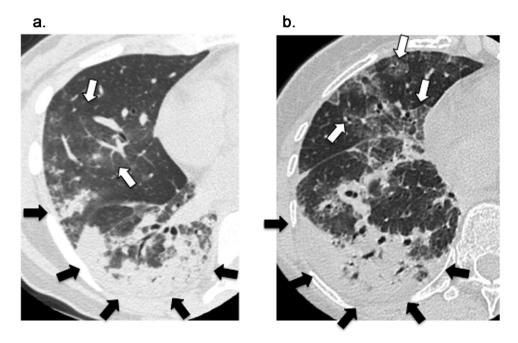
Airspace consolidation. (a) Thin-section CT scan of the right lung in a 43-year-old woman with ARS-ILD (EJ) shows areas of airspace consolidation in peripheral and peribronchovascular regions (black arrows). Areas with ground-glass attenuation are seen around those of airspace consolidation (white arrows). (b) Thin-section CT scan of the right lung in a 66-year-old man with ARS-ILD (Jo-1) presents areas of airspace consolidation in peripheral and peribronchovascular regions. Areas with ground-glass attenuation are also seen (white arrows).
